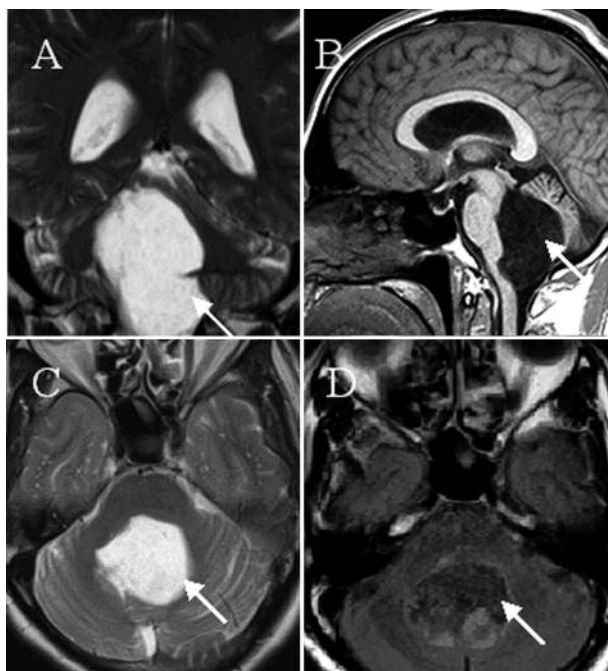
The fourth ventricular lesion was isointense to CSF on T2 weighted images (A, C), almost isointense on T1 weighted SE (B), with lack of suppression on FLAIR (D).
